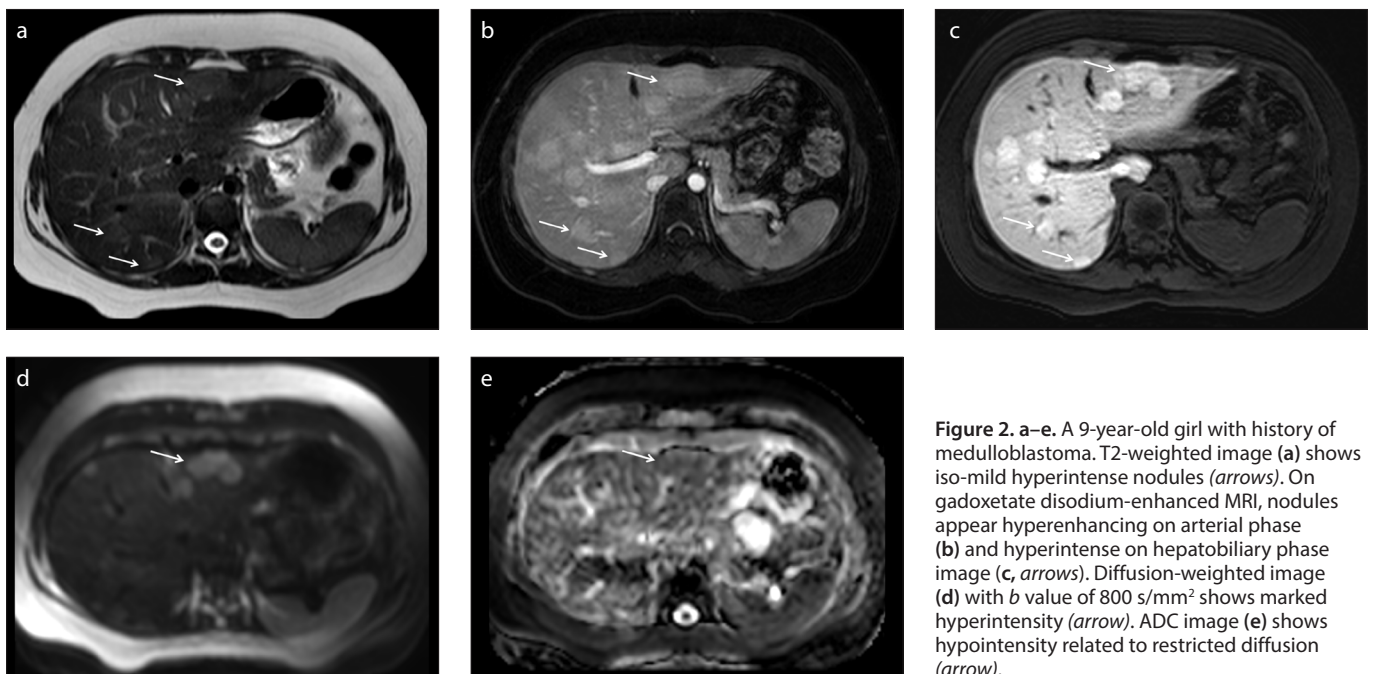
a–e. A 9-year-old girl with history of medulloblastoma. T2-weighted image (a) shows iso-mild hyperintense nodules (arrows). On gadoxetate disodium-enhanced MRI, nodules appear hyperenhancing on arterial phase (b) and hyperintense on hepatobiliary phase image (c, arrows). Diffusion-weighted image (d) with b value of 800 s/mm^2 shows marked hyperintensity (arrow). ADC image (e) shows hypointensity related to restricted diffusion (arrow).
